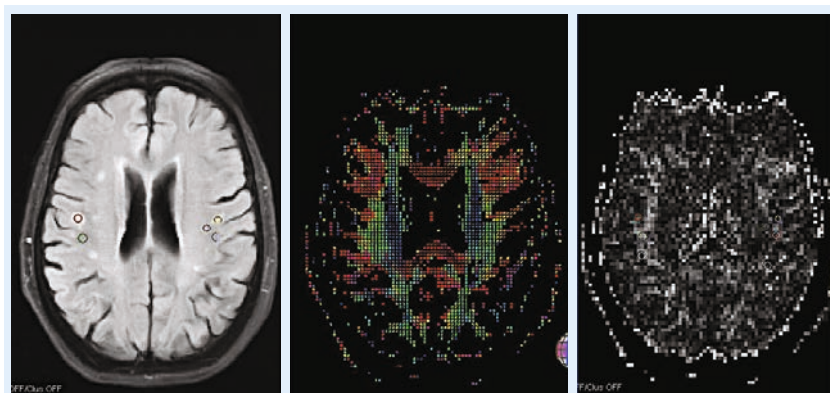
Directional diffusivity in the evaluation of a family with leukodystrophy. From left, fluid-attenuation inversion recovery, rotational atherectomy map with ellipsoid and color tensor encoding, and the corresponding radial diffusivity parameter maps. This subject is a gene carrier in a family with Pelizaeus–Merzbacher’s disease. Unlike chronic microangiopathy of the elderly, which presents with small periventricular T2 hyperintense lesions on fluid-attenuation inversion recovery and T2-weighted images, which are characterized by elevations in both axial and radial diffusivity, this subject has more peripheral lesions (circled on the fluid-attenuation inversion recovery image and corresponding radial diffusivity map), which have elevated radial diffusivity and preserved axial diffusivity. These findings are expected in a carrier of a leukodystrophy gene defect. Reproduced with permission from [3].
